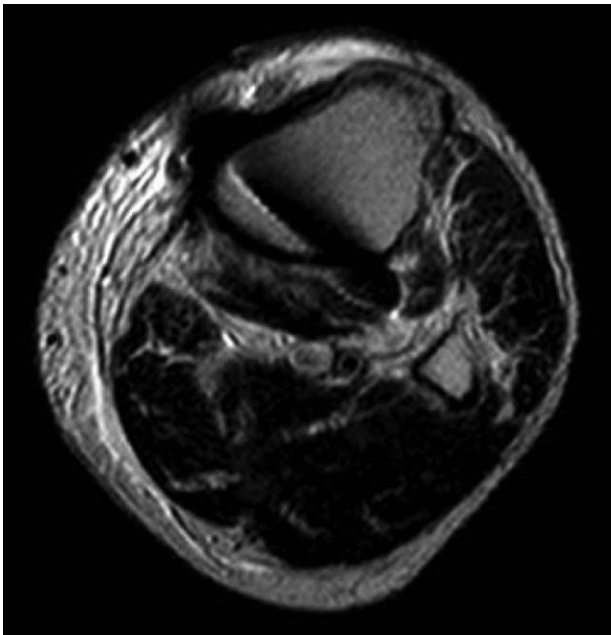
Magnetic resonance imaging was performed to rule out hematoma formation around the osteotomy site. There was a lack of hematoma formation, and the screw tip was located within the soleus muscle.
